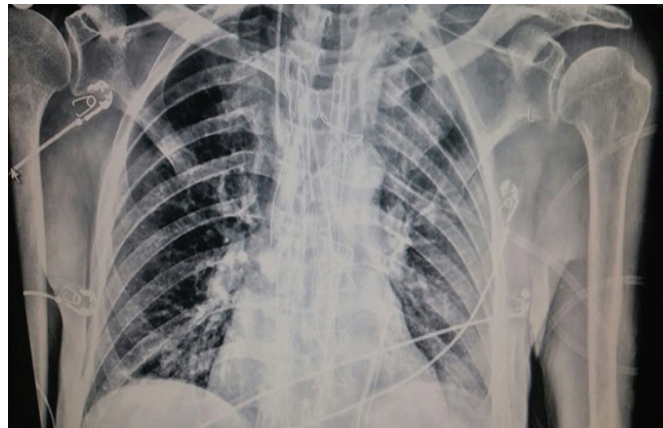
Post-operative X-ray image
